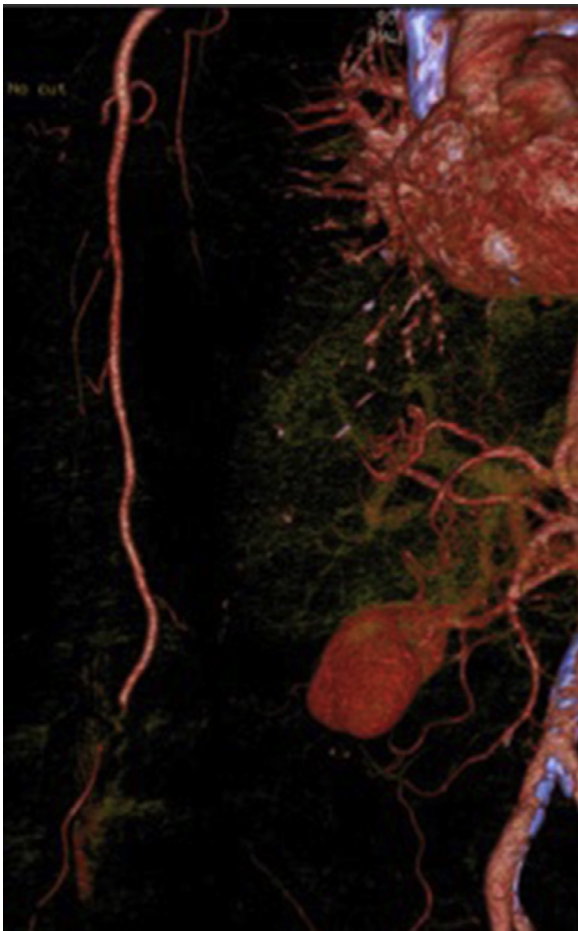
Abbreviations: CTA, computed tomography angiography; RCA, ramus circumflexus anterior; RIA, ramus interventricularis anterior.
